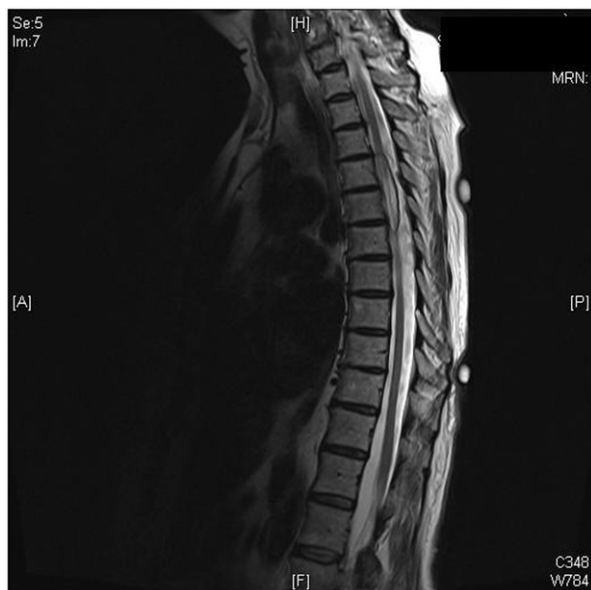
MRI T2-weighted image of the intradural thoracic lipoma. A hyperintense lesion is seen from Th4 to Th6.
